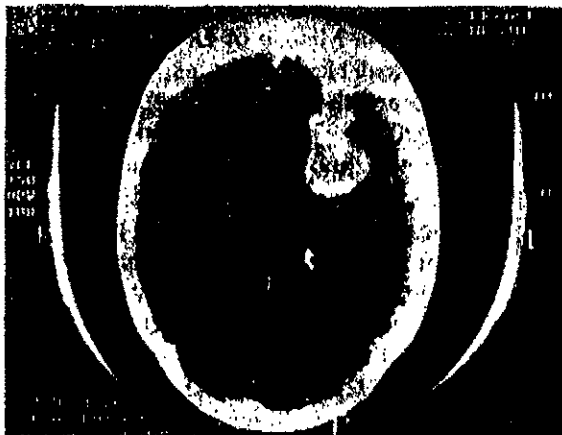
CT scan showing large intracerebral haemorrhage in the left fronto-parietal region with significant mass effect and surrounding oedema with shift of the midline.
